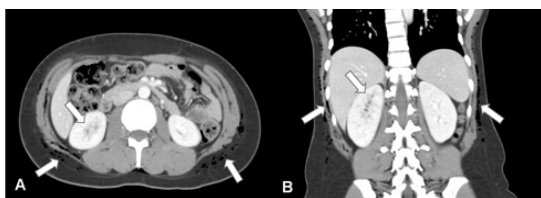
Massive subcutaneous emphysema, myositis, and pyelonephritis on right kidney from the axial view (A) and coronal view (B) in computed tomography (CT)
